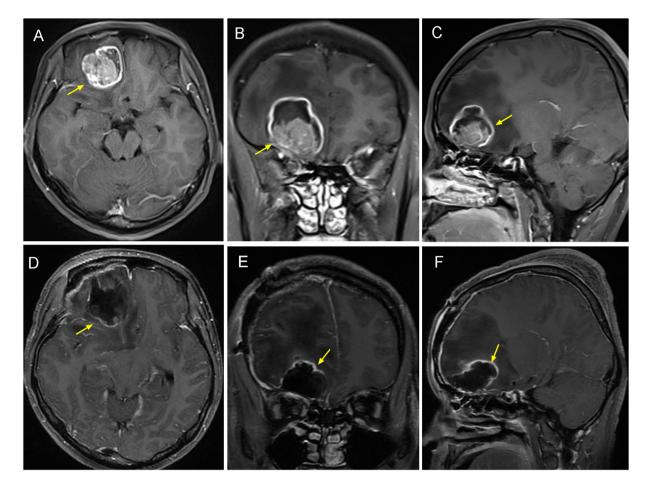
Preoperative and postoperative imaging of the intracranial tumor. (A) Axial contrast-enhanced MRI showing a right frontal lobe lesion with surrounding edema. (B) Coronal contrast-enhanced MRI showing the extent of the lesion. (C) Sagittal contrast-enhanced MRI revealing the mass effect and surrounding edema. (D) Axial contrast-enhanced MRI at 2 weeks post-surgery showing no residual tumor. (E) Coronal contrast-enhanced MRI confirming complete resection of the right frontal lesion. (F) Sagittal contrast-enhanced MRI indicating postoperative changes without evidence of tumo The yellow arrows indicate the location of the tumor.
